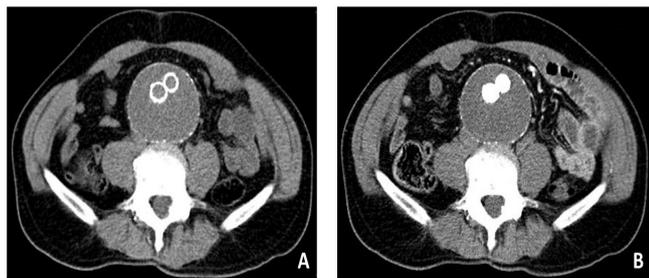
Preoperative plain and contrast-enhanced CT on endotension after EVAR (case 15). (A) On plain CT, high intensity prosthetic stent graft is seen inside enlarged abdominal aortic aneurysm. (B) On contrast-enhanced CT, stent graft lumen is well visualized with contrast agent, however no contrast agent is seen in the aortic aneurysm, suggesting no inflow vessels. CT, computed tomography; EVAR, endovascular aneurysm repair.
